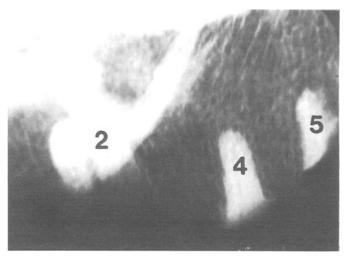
1994 postmortem radiographs, following the application of the radiopaque dental material.
